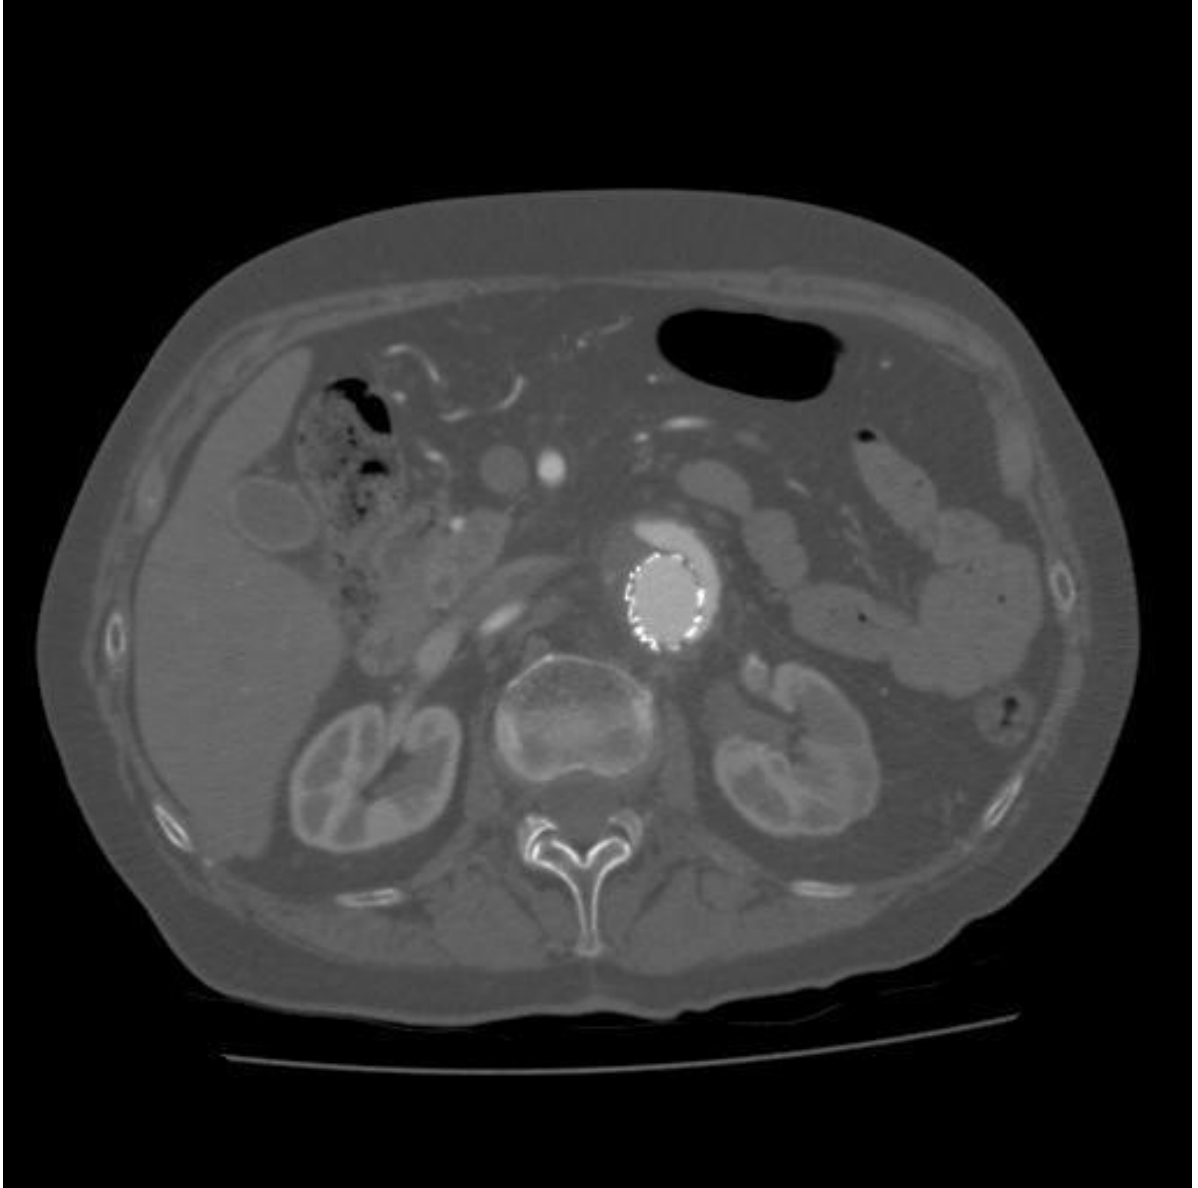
Axial CT scan image of an 80 years old female showing a type I endoleak [150].
